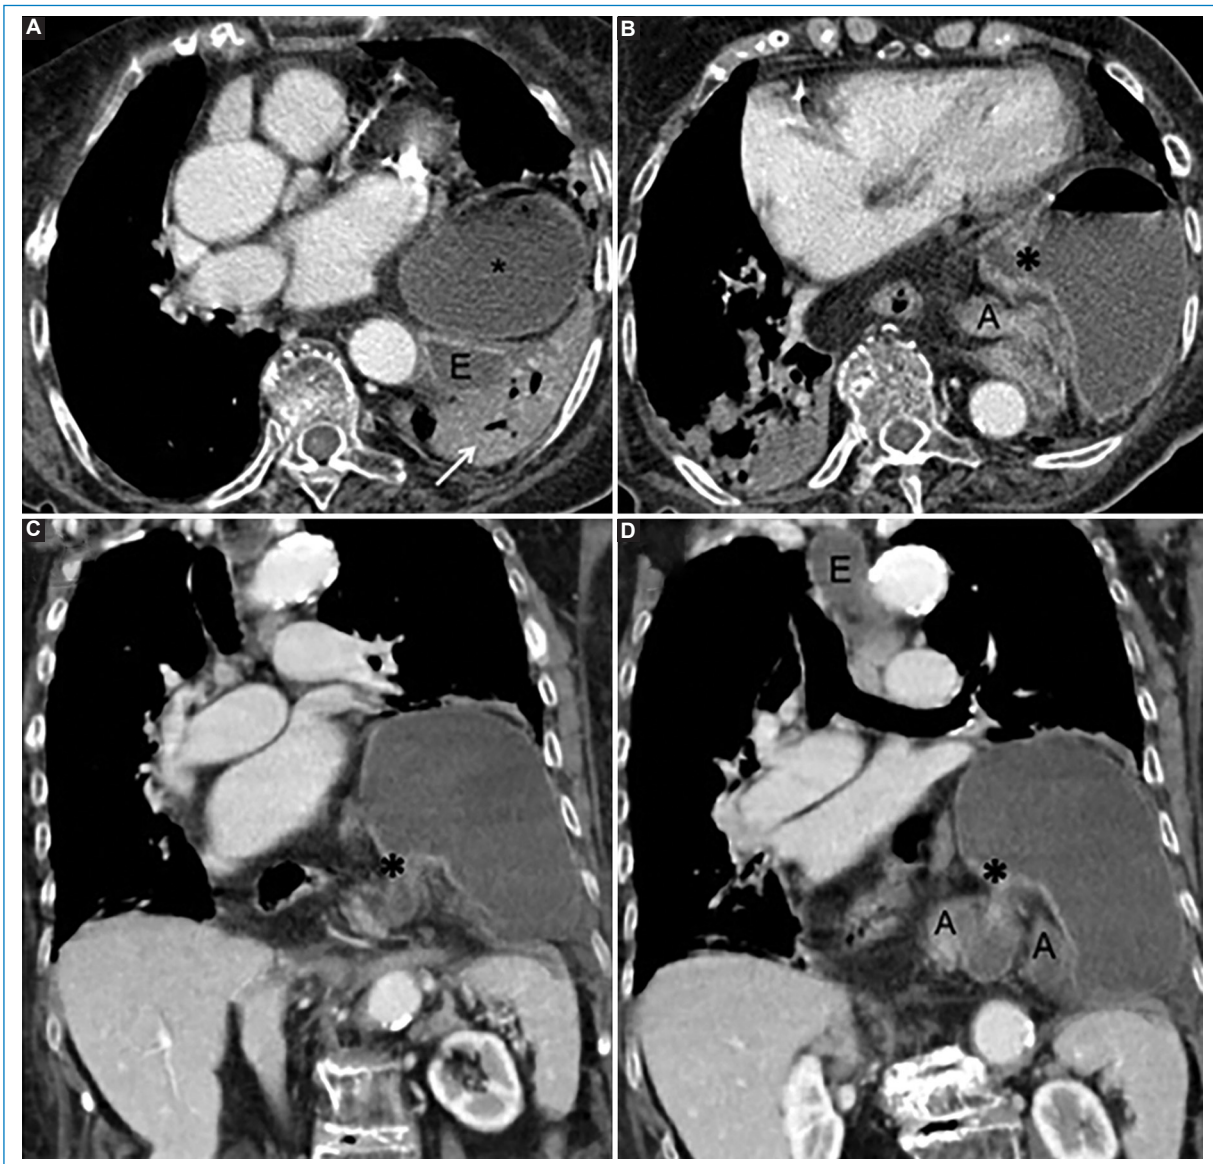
Type III hiatal hernia. Axial slices (A and B) and coronal reconstructions (C and D) of a computed tomography of the thorax, abdomen and pelvis. There is evidence of the gastroesophageal junction (asterisks) and the gastric chamber, which is slightly rotated, ascending into the thoracic cavity, with no evidence of complications. There is also secondary dilatation of the esophagus (E) and a focus of aspiration etiology condensation in the left lung base (arrow). A: antrum.
